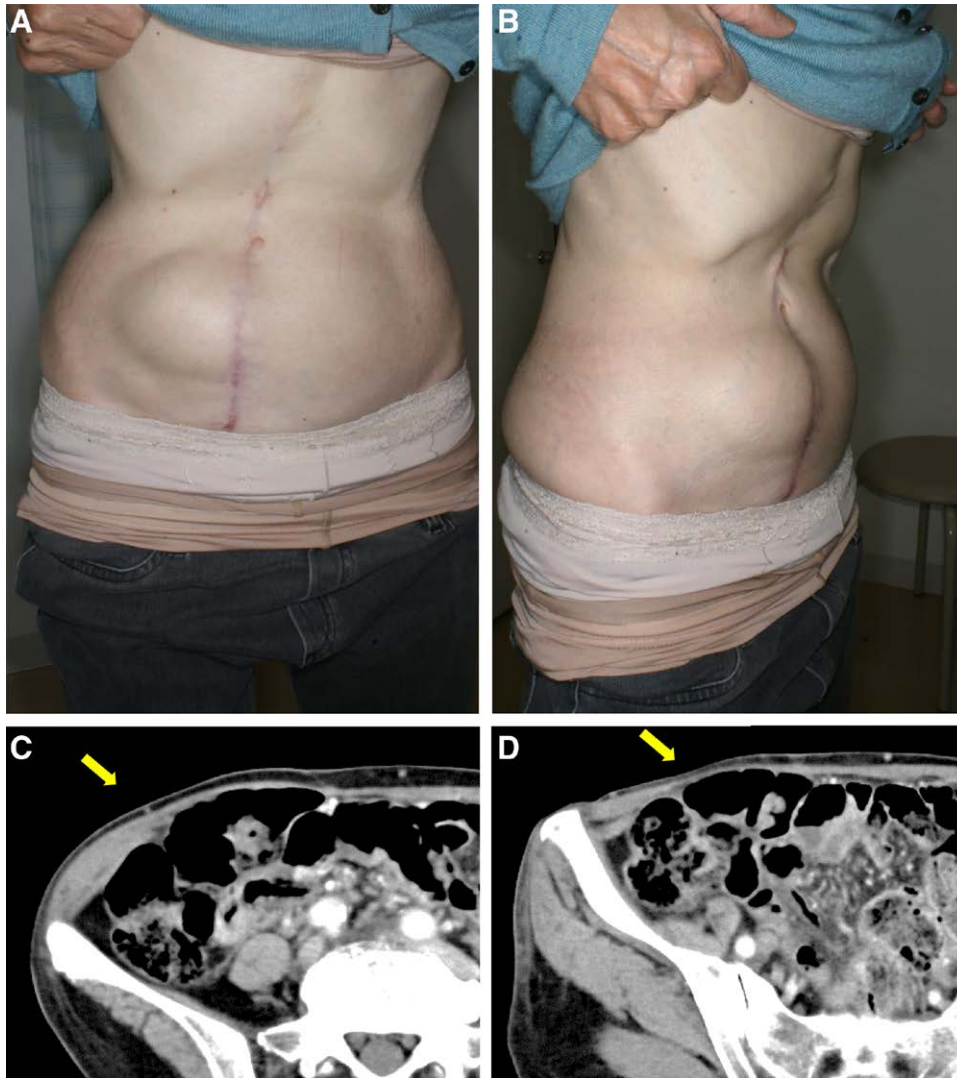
A case of abdominal bulging (No. 5 in Table 3). A, Abdominal bulging in the right abdominal flap donor-site in the standing position. B, The right lateral view confirms protrusion of the right lower abdomen. C-D, Abdominal computed tomography showing protrusion of the right abdominal wall (arrow). However, there is no bowel herniation outside the abdominal wall.
